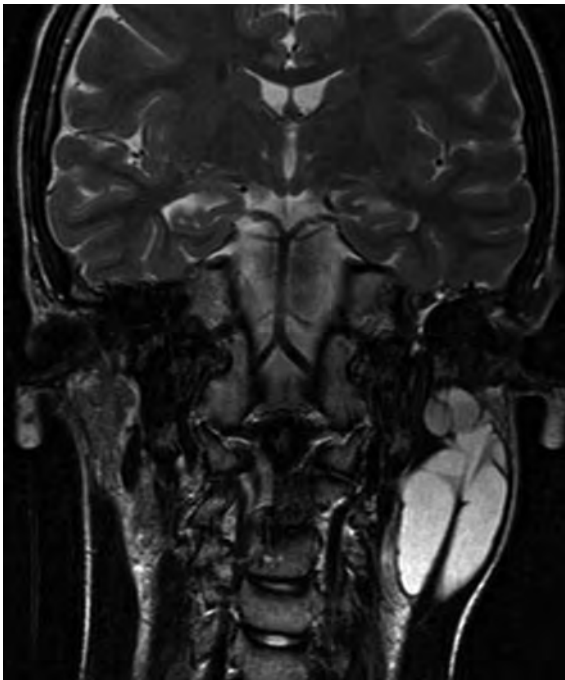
Cystic lymphangioma of the inferior pole of the left parotid gland. Typical aspect of a lobulated, septated, cystic mass showing a high T2-weighted signal intensity
